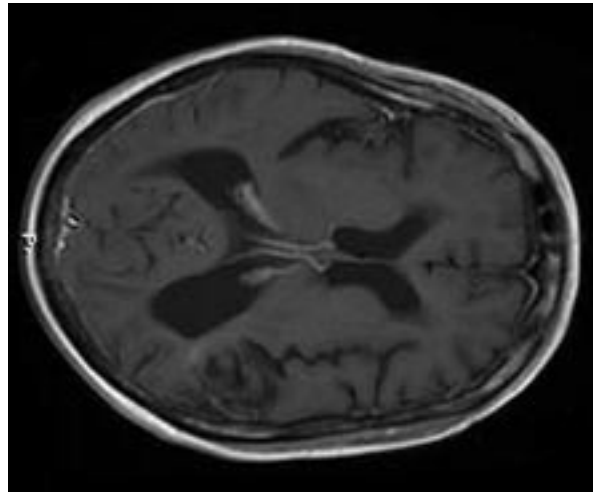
Magnetic resonance image showing a large temporal lobe lesion.
